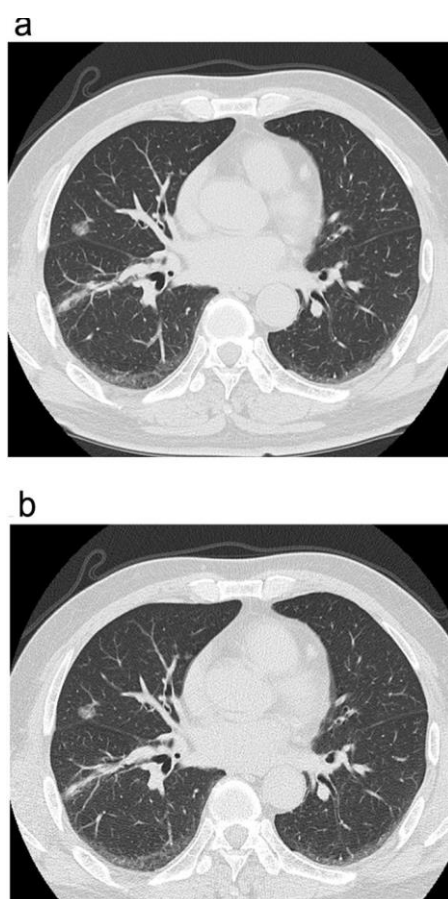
(a, standard dose image; b, low dose image) 67-year-old male who had a chest CT examination for evaluation of a suspected nodule in the right middle lobe which turned out to be lung cancer(9).
